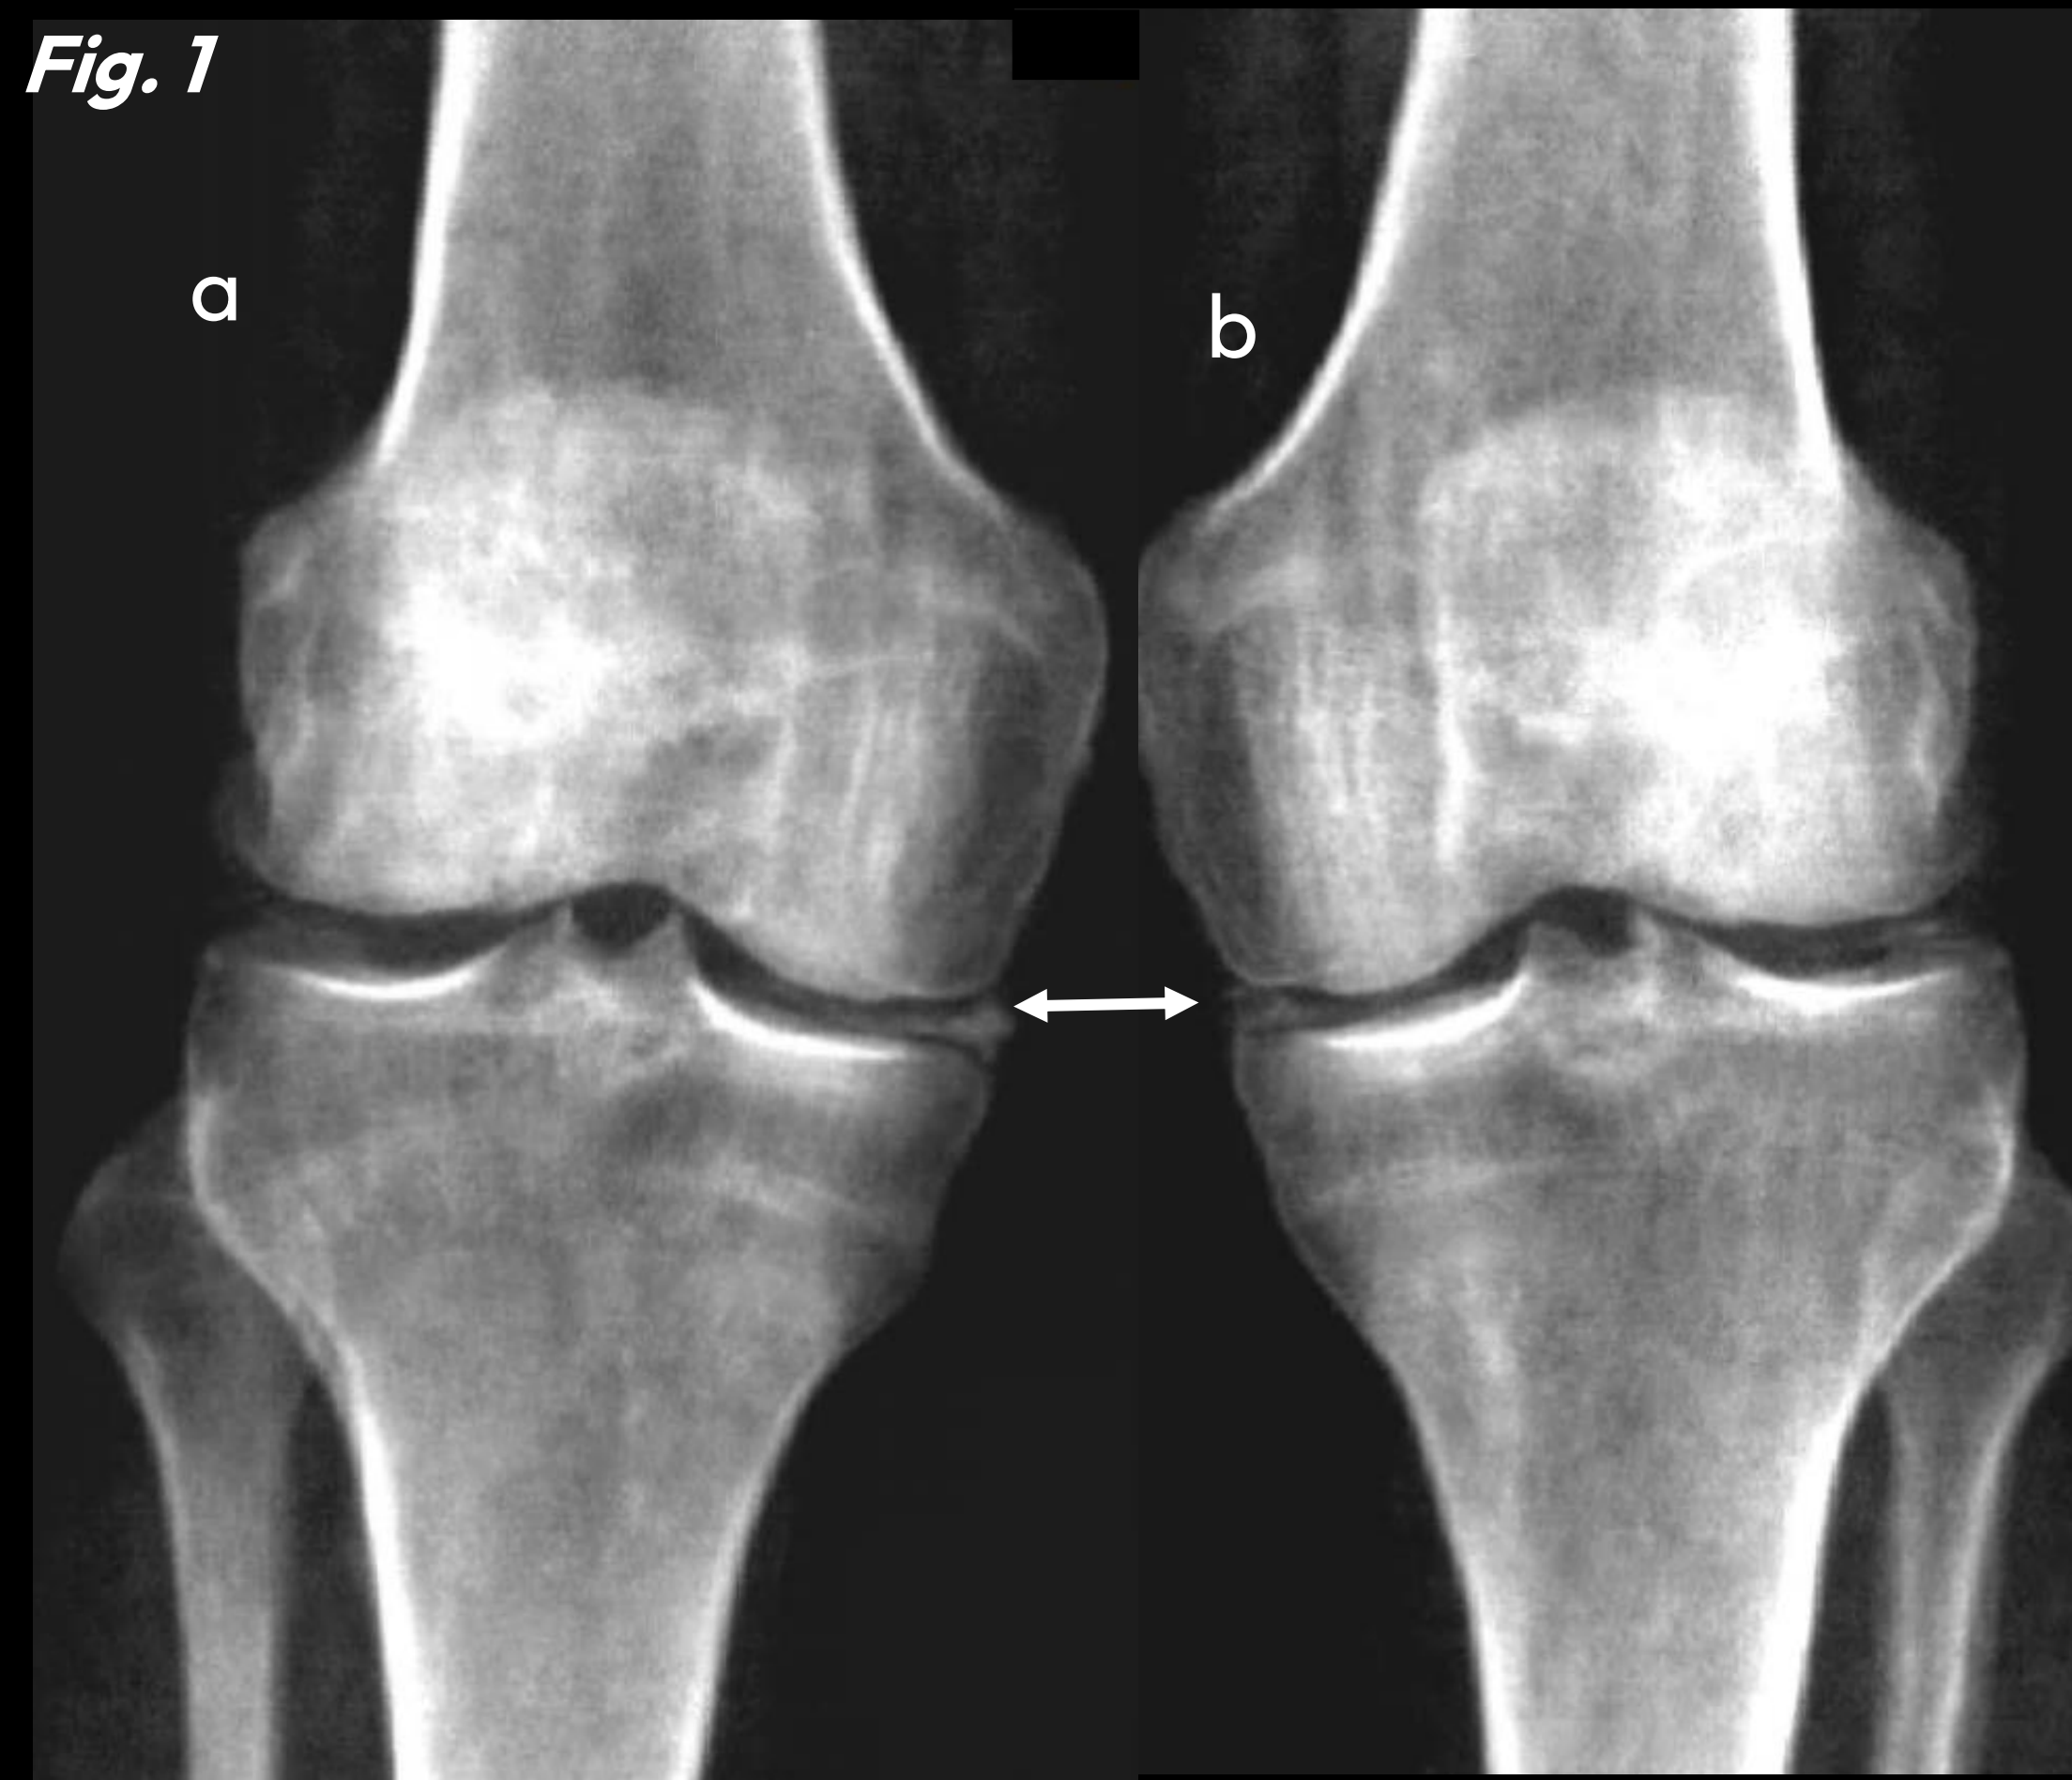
Image analysis: 264 Posteroanterior (PA) DXA scans of both knees (Fig.1) were reviewed for radiological evidence of chondrocalcinosis by an experienced reporting radiographer, blind to case/control.
